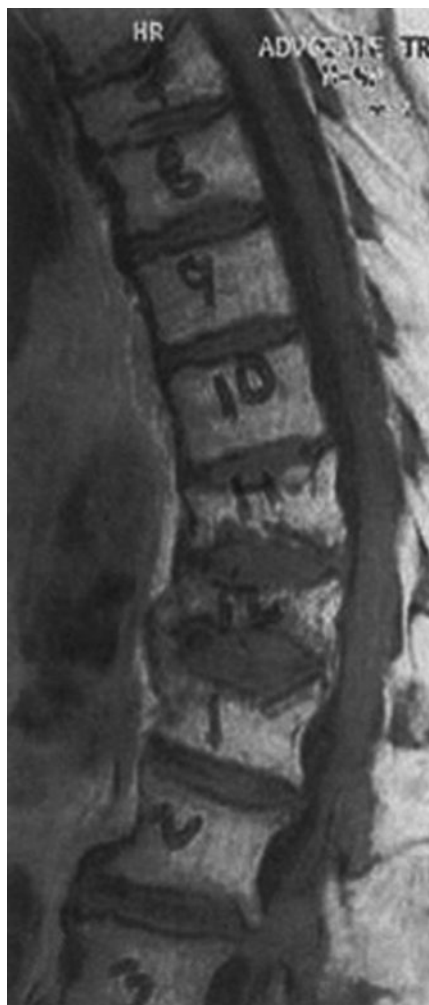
Vertebral fractures. MRI of the thoracic and lumbar spine showing multiple vertebral fractures (T7, T11, T12, L1, and L2).
